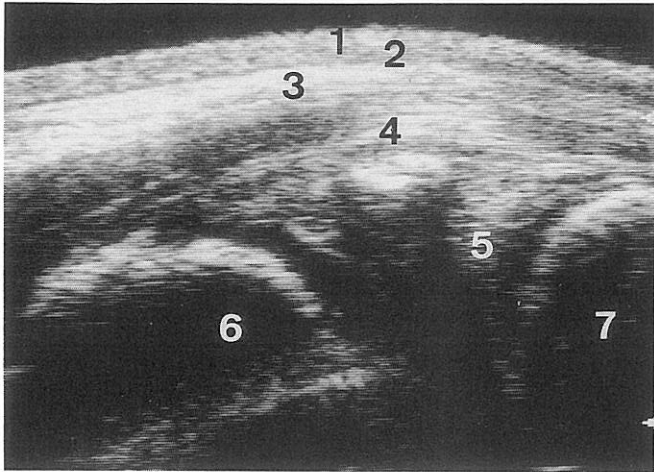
Longitudinal (frontal) ultrasound scan performed at the medial aspect of the femorotibial joint of a 3 year-old male, selle français.
